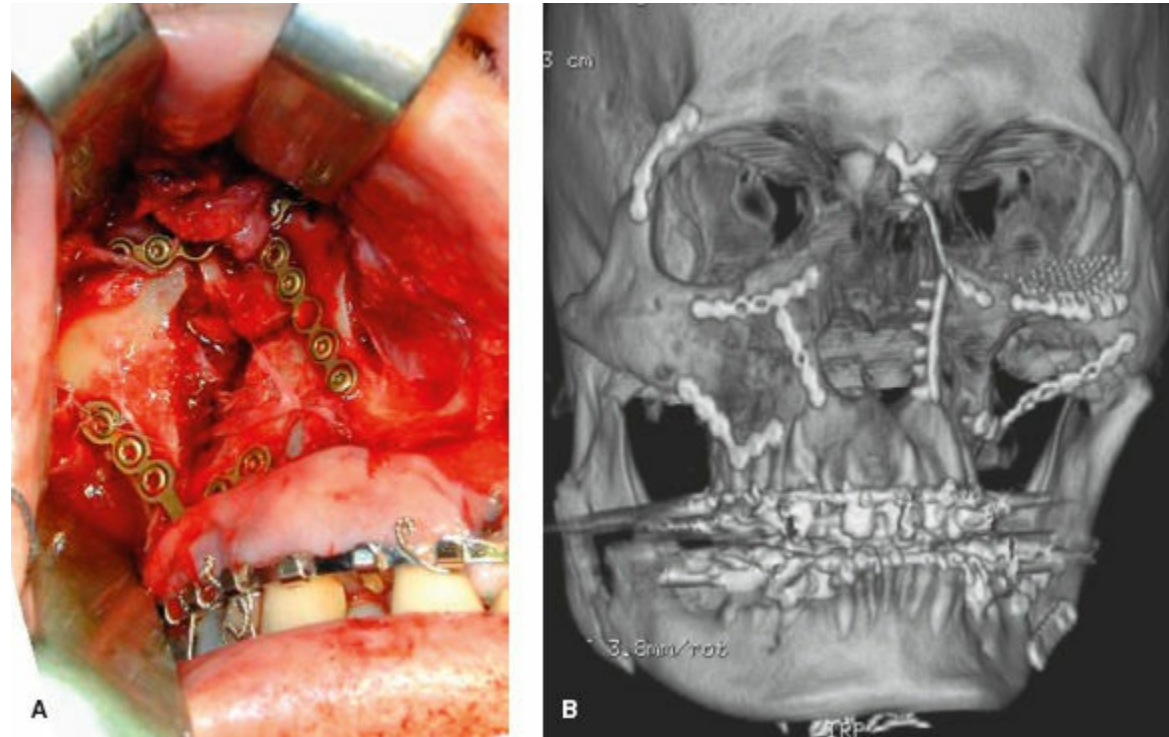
Same patient after open reduction and internal fixation of the bilateral Le Fort I, II, and III fractures, after repairing the mandible and using the occlusion as a guide to work from bottom-up. A: Intraoperative photos of Le Fort I ORIF. B: Postop CT scan.
